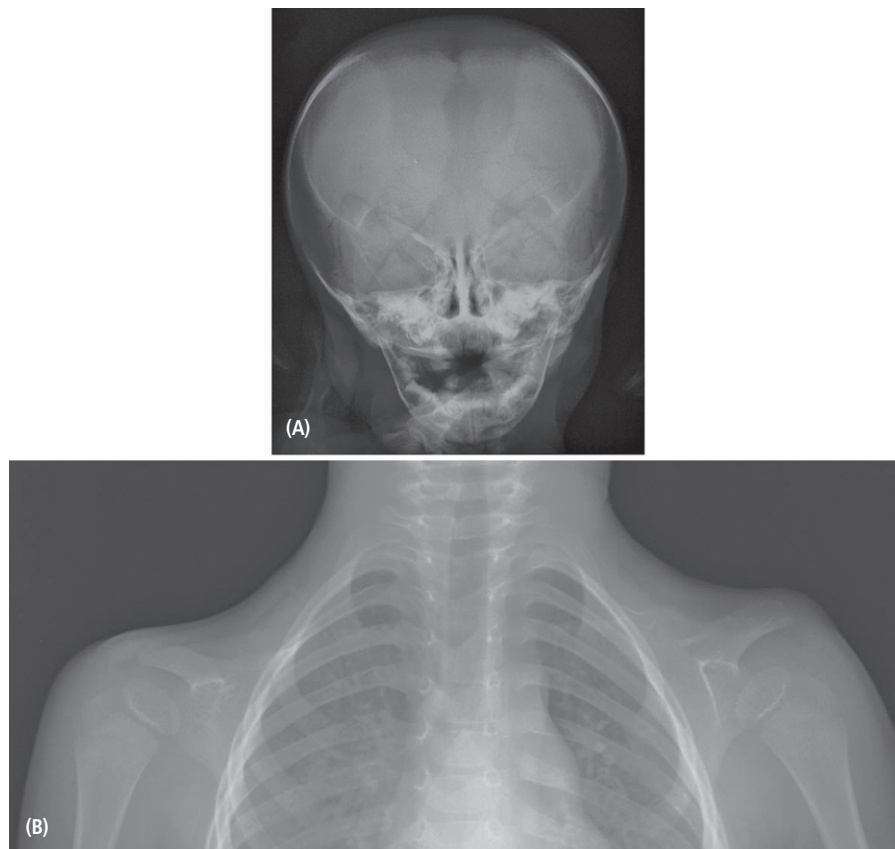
Radiographic analysis of the skeleton of the 10-year-old boy seen in Case 2. (A) Skull radiograph taken at one year of age; and (B) chest radiograph taken at five years of age. Note the large fontanelle and absence of clavicle.
